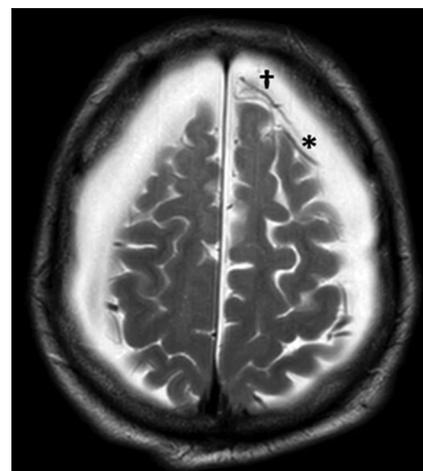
Brain MR T2-weighted axial images showed the coexistence of the cortical vein sign (black asterisk) and the “anti-cortical” vein sign (black obelisk).
